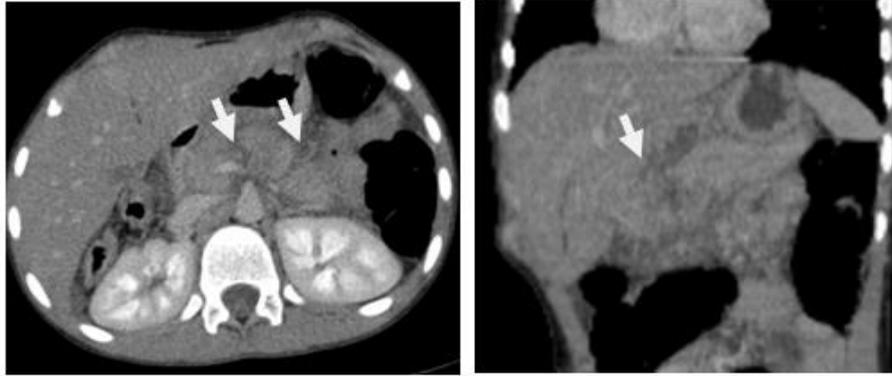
Contrast-enhanced CT scan of abdomen and pelvis demonstrating transection at the junction of the pancreatic neck and body (arrows)
